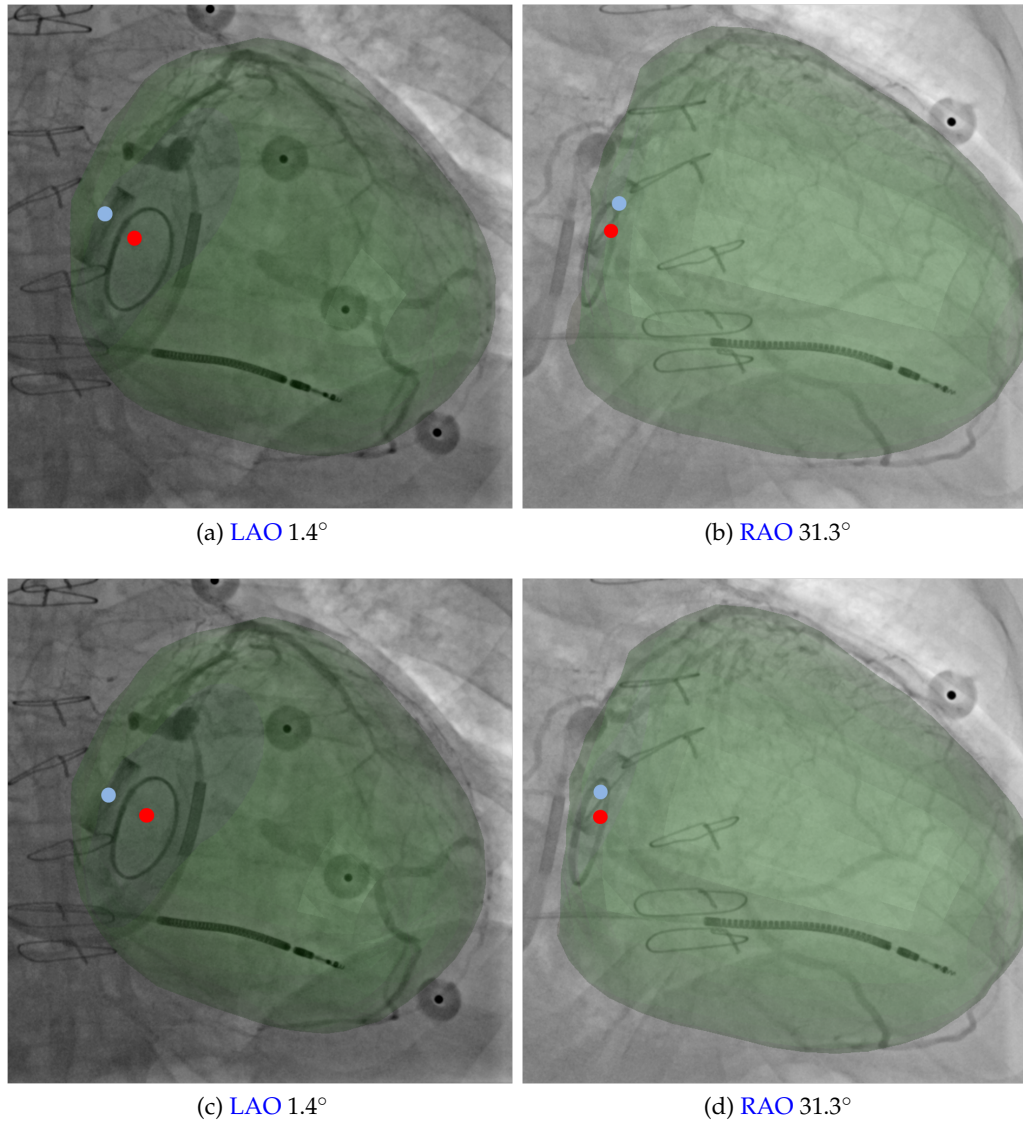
Registered epicardial mesh (green), aortic valve centroid (blue), and mitral valve centroid (red) overlaid. (a, b) X-ray views of registration with known vessel correspondences. (c, d) X-ray views of registration with super-abundant vessel point cloud.
